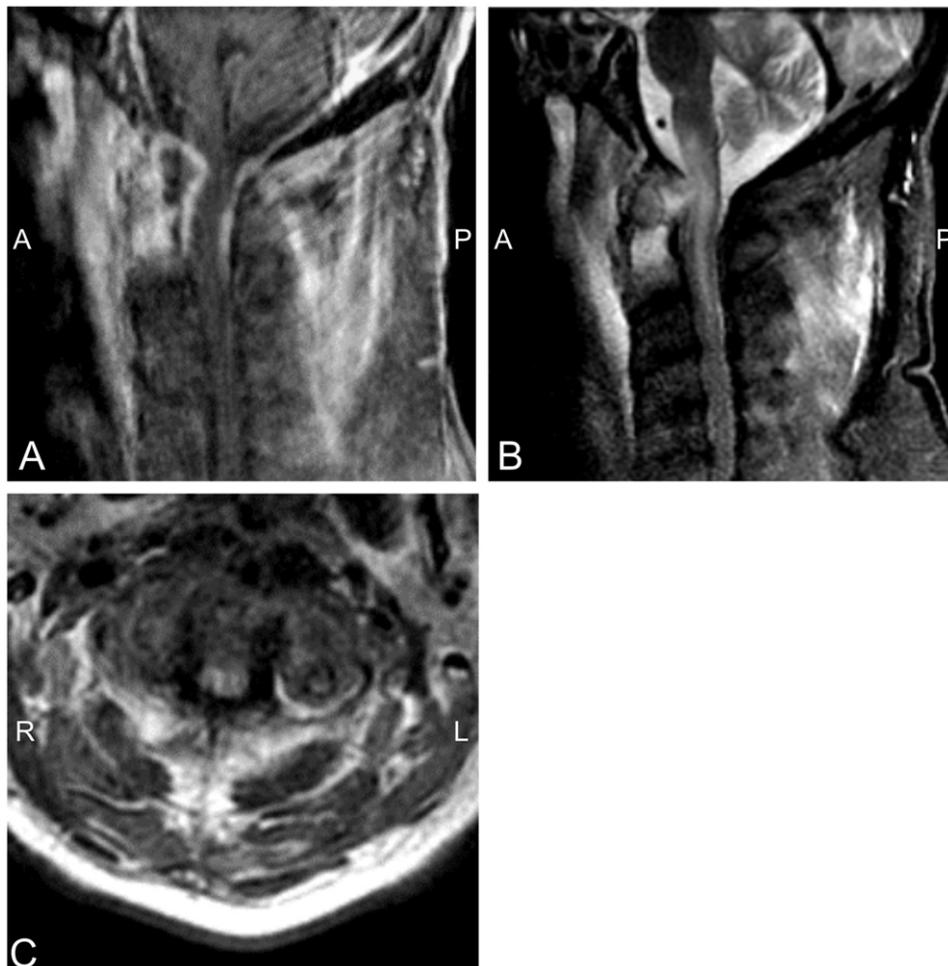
Pre-operative MRI imaging reveals epidural abscess, osteomyelitis, and compression of the cervical spinal cord. A) T1 sagittal view demonstrates a 2.2×2.0 cm rim-enhancing lesion in the anterior epidural space posterior to the tip of the dens causing compression of the cervicomedullary junction. Osteomyelitis is present at the C1 and C2 vertebrae. B) STIR sagittal view demonstrates severe cord compression at the cervicomedullary junction abnormal cord signal from the inferior medulla to the C3 vertebral level. CSF flow is severely obstructed anteriorly and minimal posteriorly. C) T1 axial view reveals cord compression anteriorly by the phlegmon mass at vertebral level C1.
